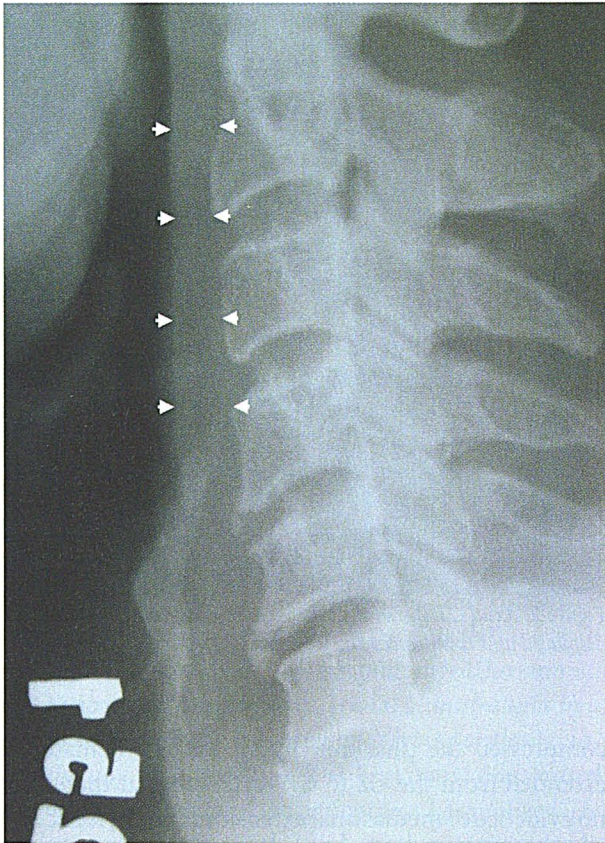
Post-treatment x-ray shows significant resolution of the hematoma (arrowheads).
